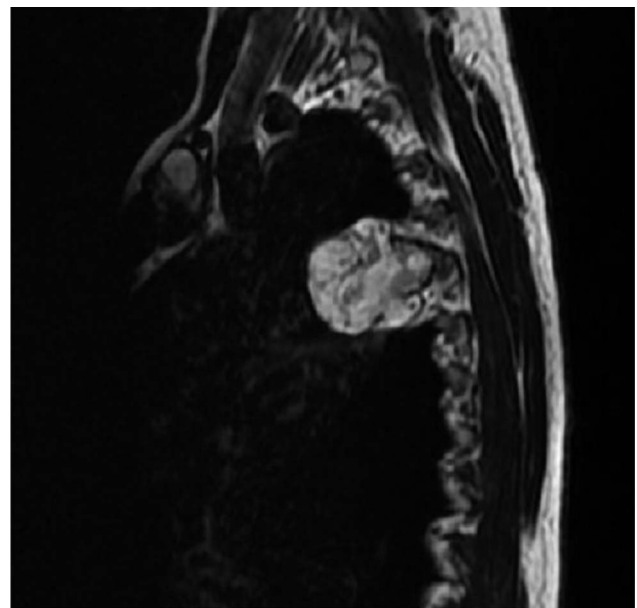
A thoracic sagittal plane T2 weighted magnetic resonance imaging show a heterogeneous mass at the right fifth–sixth costo-vertebral angle measuring 53–36 mm, 1 year preoperatively.
